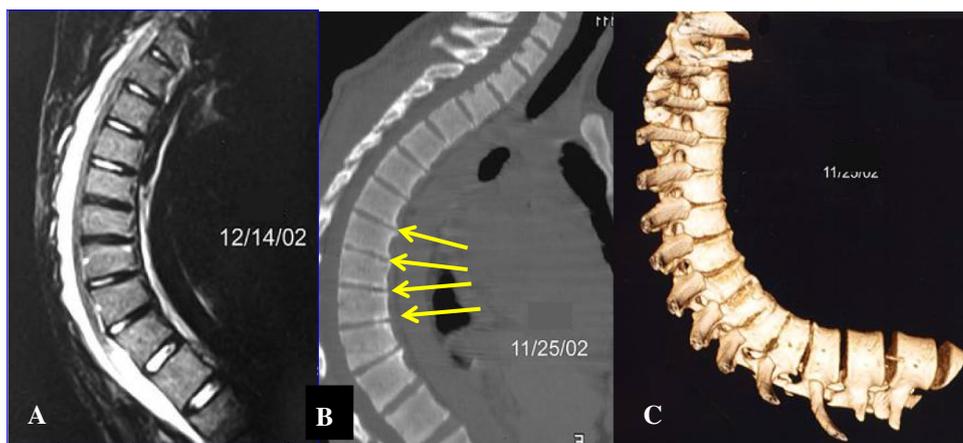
Pre-revision sagittal MRI (a), 2D CT scan (b), and 3D CT scan (c) showing narrowed but unfused apical discs
